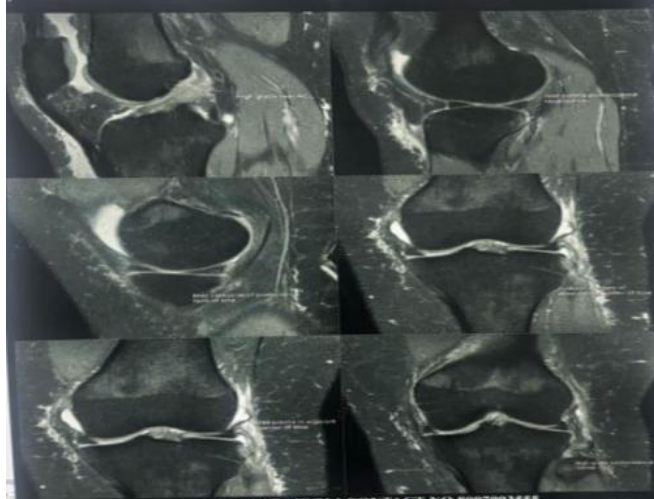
MRI of the Left Knee Joint Showing ACL Injury
